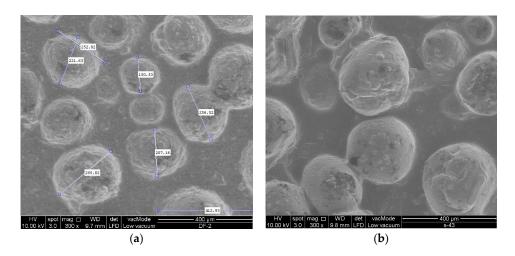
(a) SEM image of ADN produced via ultrasound sonication, following by coating with 5% of PS. The particles diameter ranges from 150 μ m to 295 μ m; (b) SEM image of ADN sonicated and coated with HTPB. The particle diameter ranges from 155 μ m to 305 μ m.
